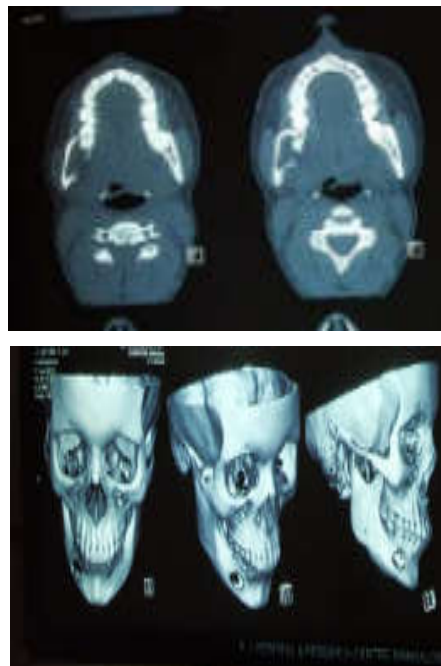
and 5 CT & CBCT showing expansile osteolytic lesion with a few straight internal septa and focal destruction of inner and outer cortices
